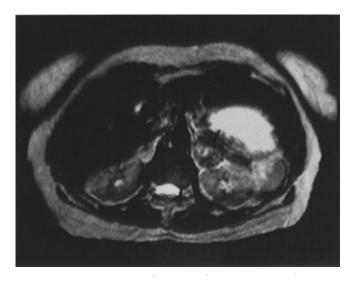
MRI of the abdomen showing a 3.5-cm mass in the left adrenal (arrow). The patient underwent successful laparoscopic left adrenalectomy using the transabdominal flank approach.
